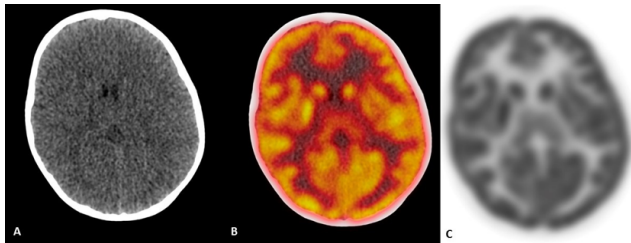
FDG PET CT, Plain CT; A: Fusion PET CT showing bilateral thalamic hypometabolism; B: Dedicated FDG Brain PET; C: Image showing bilateral thalamic hypometabolism.
